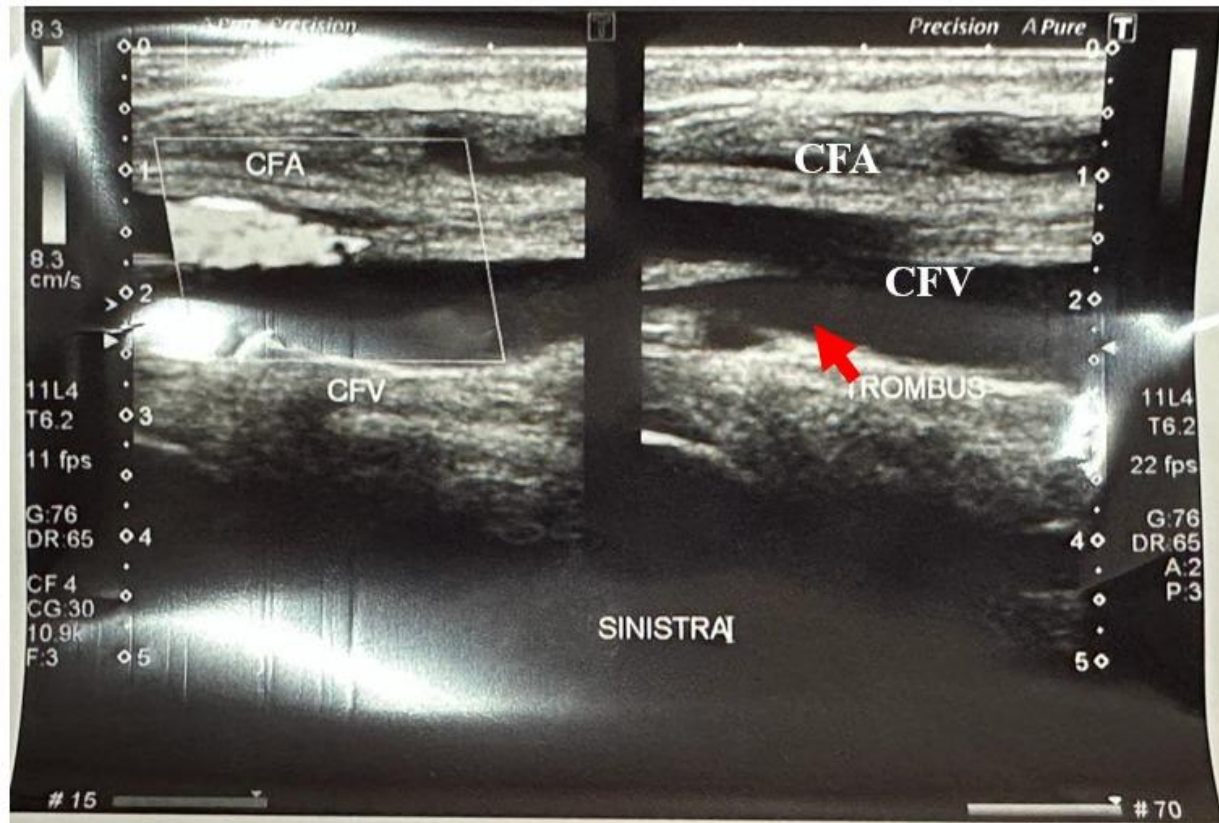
The patient's vascular duplex ultrasonography shows a reduced thrombus (red arrow) at the left common femoral vein (CFV).
